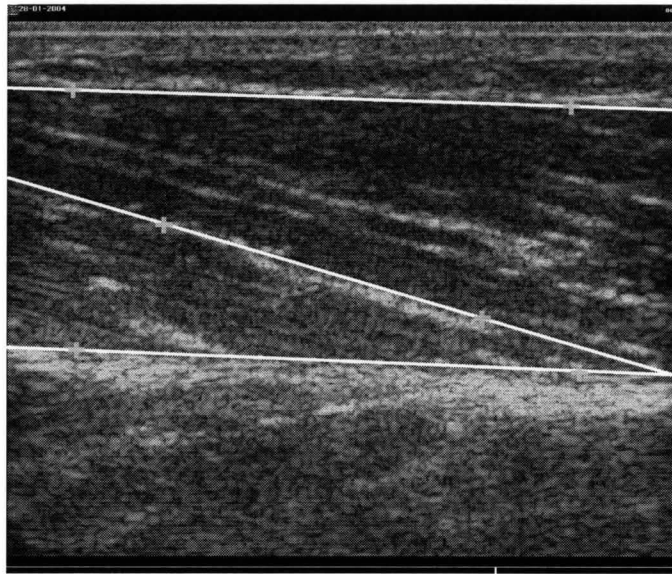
The cursor and line locations on the ultrasound image.
